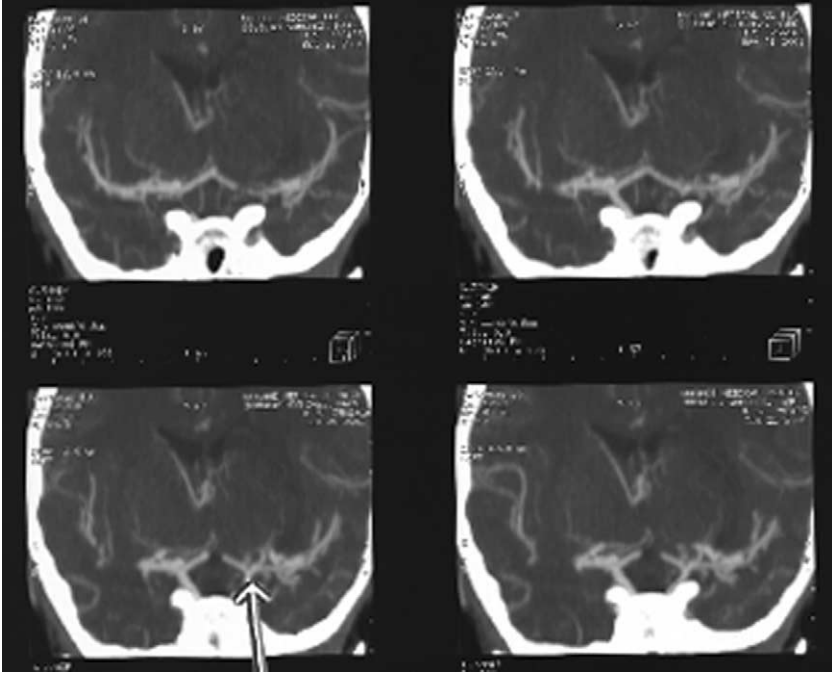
Coronal CT angiography in a 15-year-old boy with acute onset right hemiplegia after a neck injury shows diminished caliber of the left supraclinoid carotid consistent with nonocclusive dissection (*arrow*).
